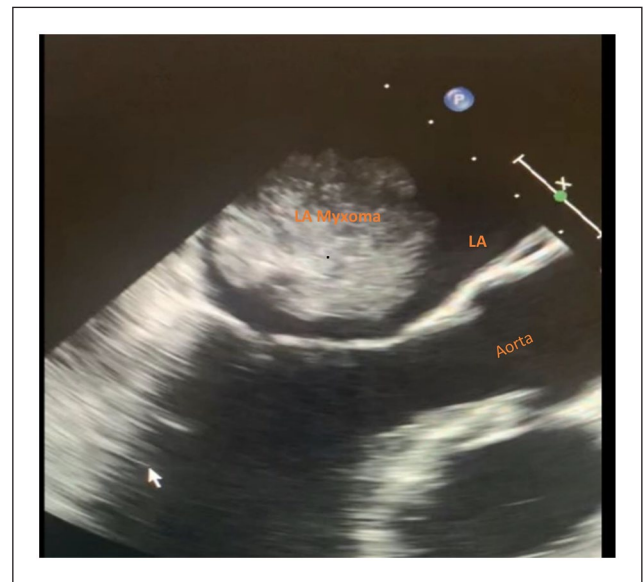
Transesophageal echocardiogram of the same patient showed a large echodense mass, the myxoma in the left atrium (LA).
